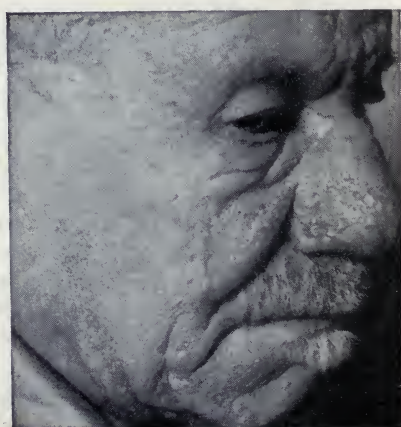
Rhinophyma after combined electro-surgery and roentgen-ray.
